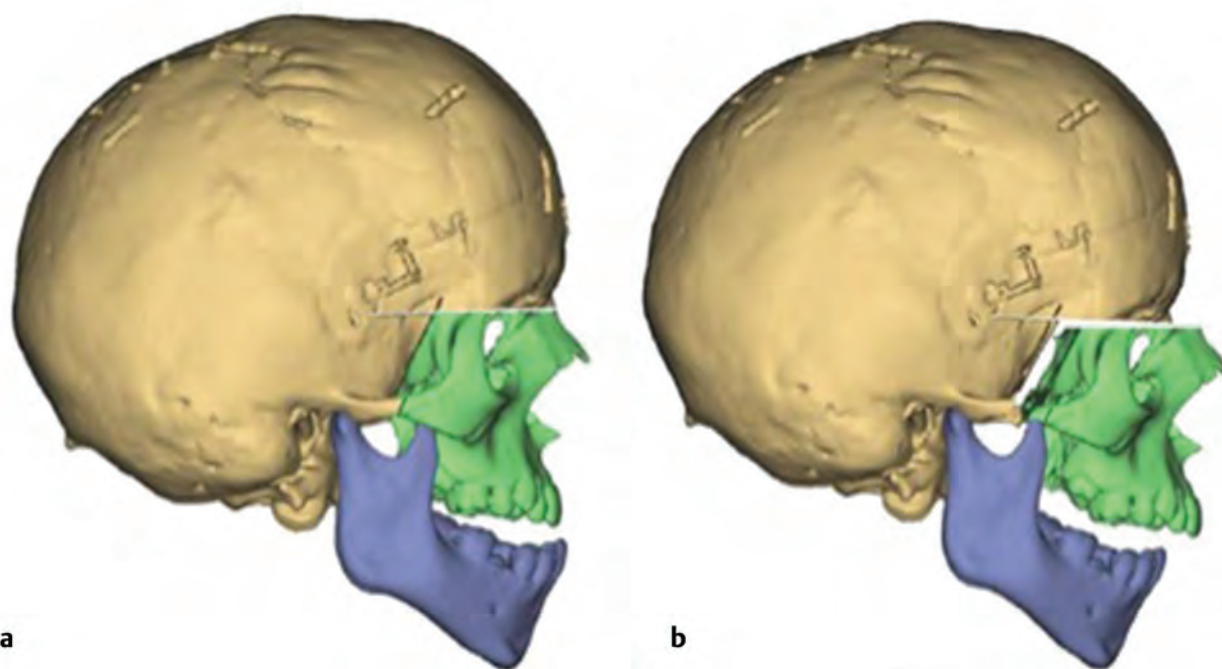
Le Fort III 3D CT advancement plan for a patient with Crouzon's syndrome (a,b).
